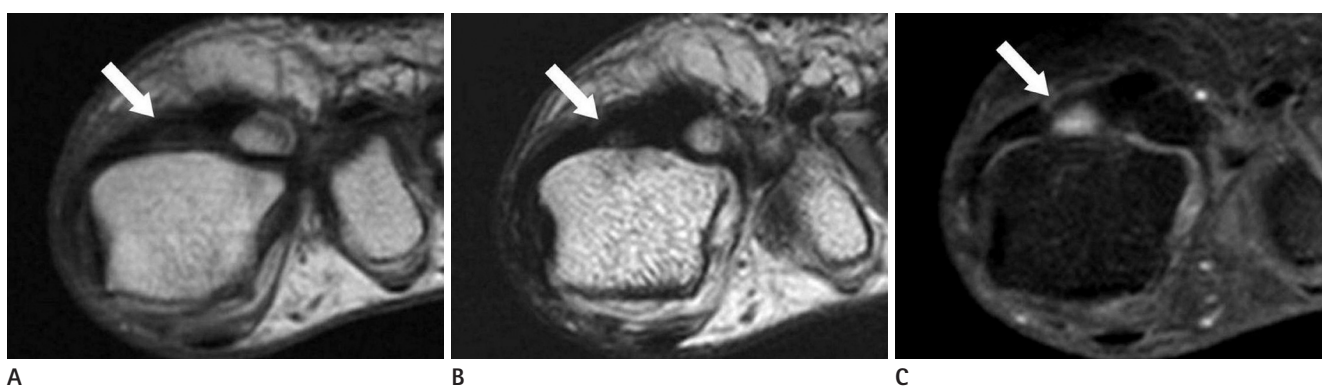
Magnetic resonance image (MRI) of the right foot.
